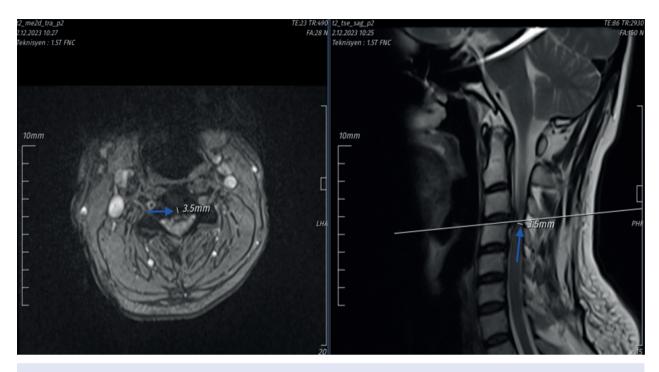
Cervical MRI image (channel diameter at MSCC level:3.5 mm).
